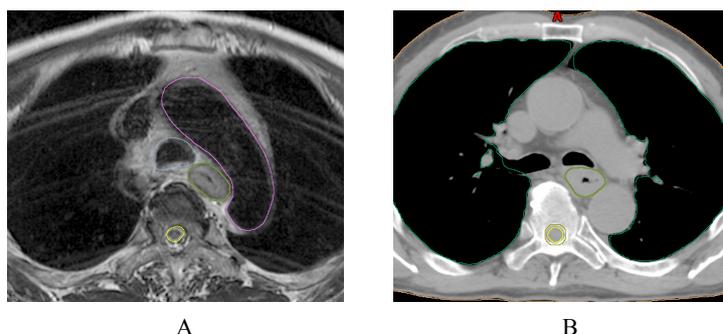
The oesophagus tumour (green) delineated on an MR image (A) and on a CT image (B). In the MR image the OARs have been delineated, aorta (pink), spinal cord (yellow) and the trachea (blue).
